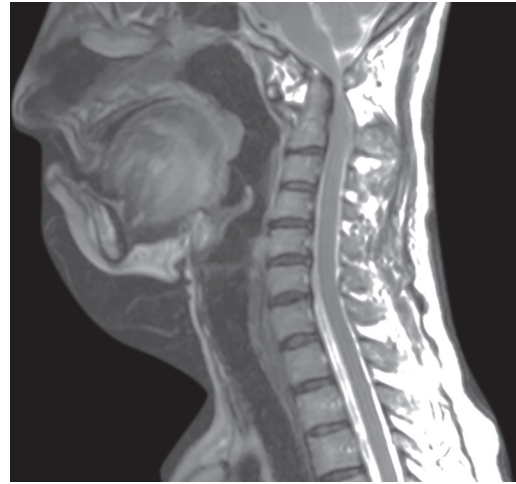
Preoperative MRI (T2) showing severe compression of cord at the cervicomedullary junction due to occipito-C1 to C2 subluxation
